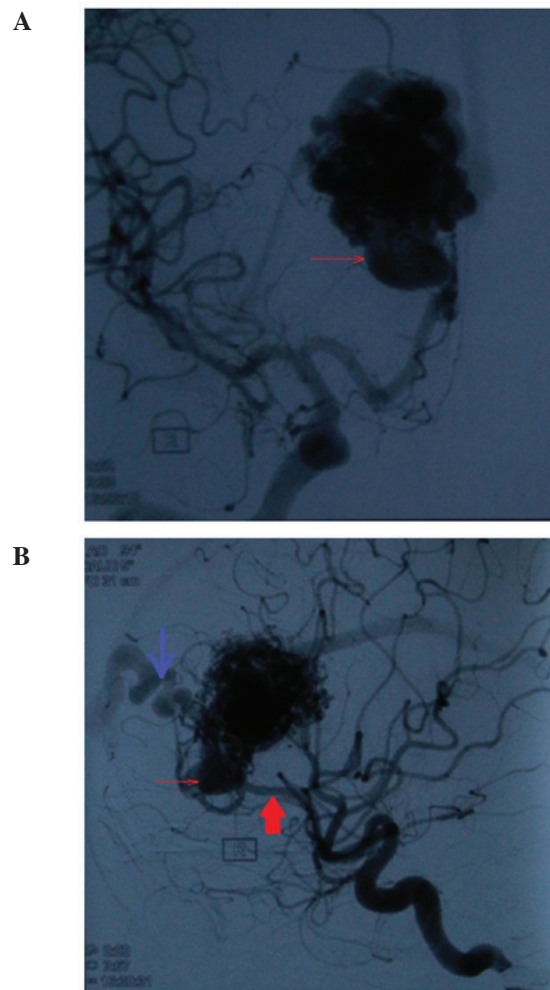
Preoperative digital subtraction angiography confirmed the results of the computed tomography scan and magnetic resonance imaging. (A) Venous phase, a large AVM and aneurysm are present, and the thin red arrow points to the aneurysm; (B) arterial phase, the blue arrow points to the draining vein, the thick red arrow points to the feeding artery and the thin red arrow points to the aneurysm.
